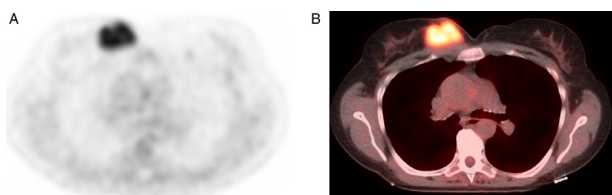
66-year-old female with a history of marginal zone lymphoma involving the left orbit treated with radiation who presented presenting with a new right breast mass. Mammographic and ultrasound workup was consistent with marginal zone lymphoma of the right breast. Axial PET and fused PET-CT images ([Figure 4A](#), [4B](#)) from initial staging demonstrated hypermetabolic activity associated with the large medial right breast mass. No other hypermetabolic areas of lymphomatous involvement were identified throughout the remainder of the body.
